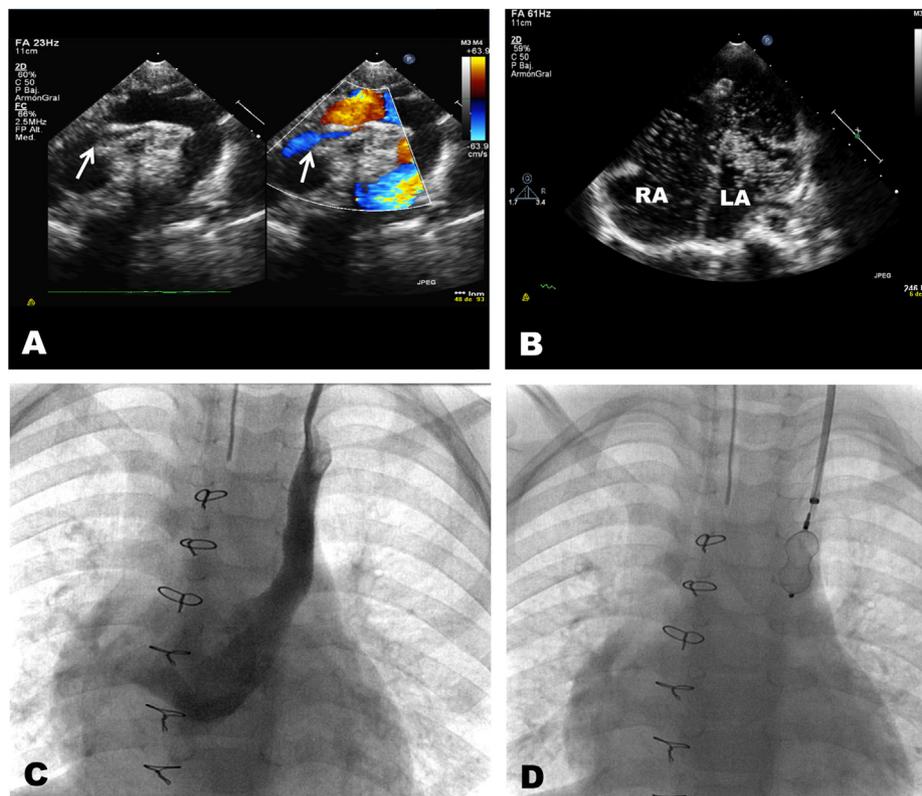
Diagnostic images. A. Transthoracic suprasternal long-axis echocardiography, showing the left superior vena cava (LSVC) draining into the right superior vena cava behind the aorta (white arrow). B. Transthoracic echocardiography apical four-chamber view during an air-bubble study, showing that after injection of agitated serum through a vein in the left arm, the bubbles first enter the left atrium (LA). C and D. Angiographic images showing the LSVC draining into the roof of the LA (C), and the releasing of the percutaneous closure device (D). RA: right atrium.
